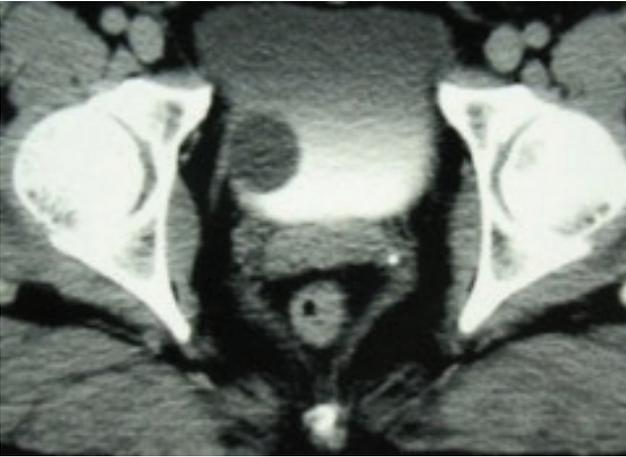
Computed tomography scan revealed a cystic mass in the right wall of the bladder that had a density of 15-30 Hounsfield Unit without enhancement.
